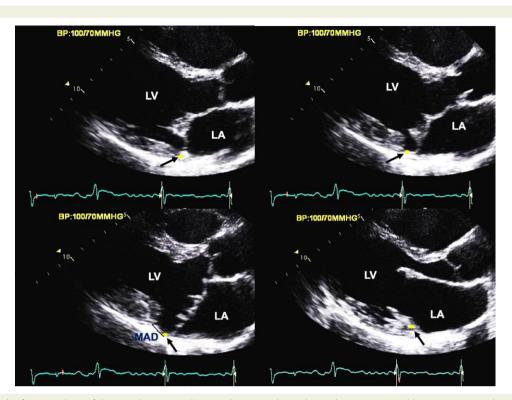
Frame-by-frame analysis of the mitral apparatus by transthoracic echocardiography in parasternal long-axis view within the entire cardiac cycle. (Upper-row left) Yellow dot with single black arrow characterizing the position of the posterior mitral annulus in early systole and (upper-row right) mid-systole. Note the prolapse of the mitral leaflets appearing in mid-systole, more pronounced on the posterior leaflet, and the absence of posterior annular disjunction yet. (Lower-row right) Late-systole view showing bileaflet mitral valve prolapse with mitral annular disjunction (black bracket) defined as a detachment of the posterior mitral annulus (yellow dot single black arrow) from the adjacent left ventricular myocardium. (Lower-row right) Early diastole view showing restored continuity between the insertion of the posterior leaflet on the mitral annulus and the left ventricular myocardium, emphasizing the necessity of image-by-image analysis of the mitral valve for mitral annular disjunction measurement in end systolic view after identification of the insertion of the posterior mitral valve leaflet in early systole. LA, left atrium; LV, left ventricle; MAD, mitral annular disjunction.
